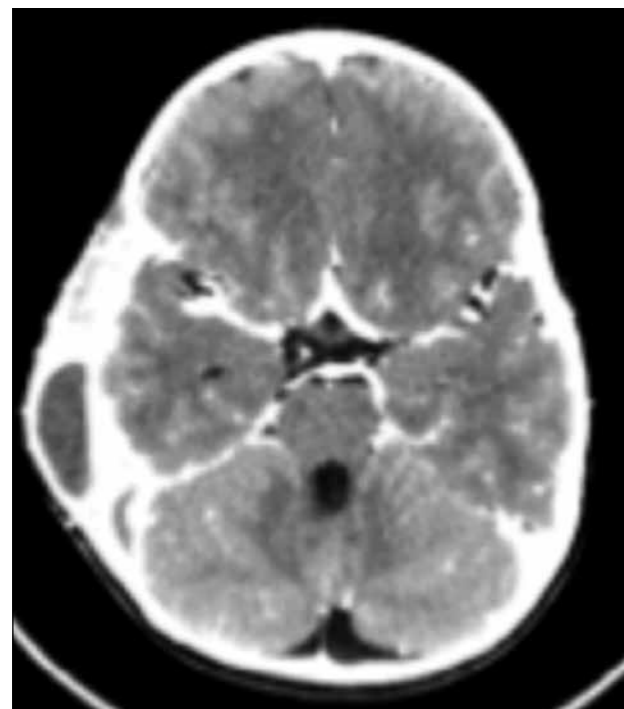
CT scan with contrast showing an otogenic brain abscess
